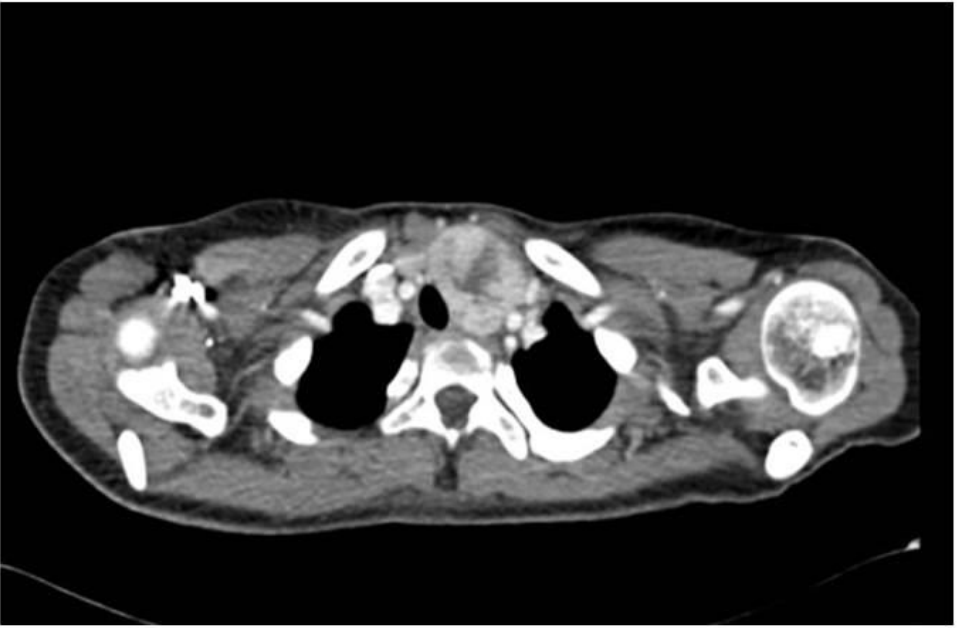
Volumetric CT post CM. Axial plane; thoracic outlet metastasis; solid heterogeneous lesion with CE at the thoracic outlet in the left- median site, trachea is dislocated and compressed.
